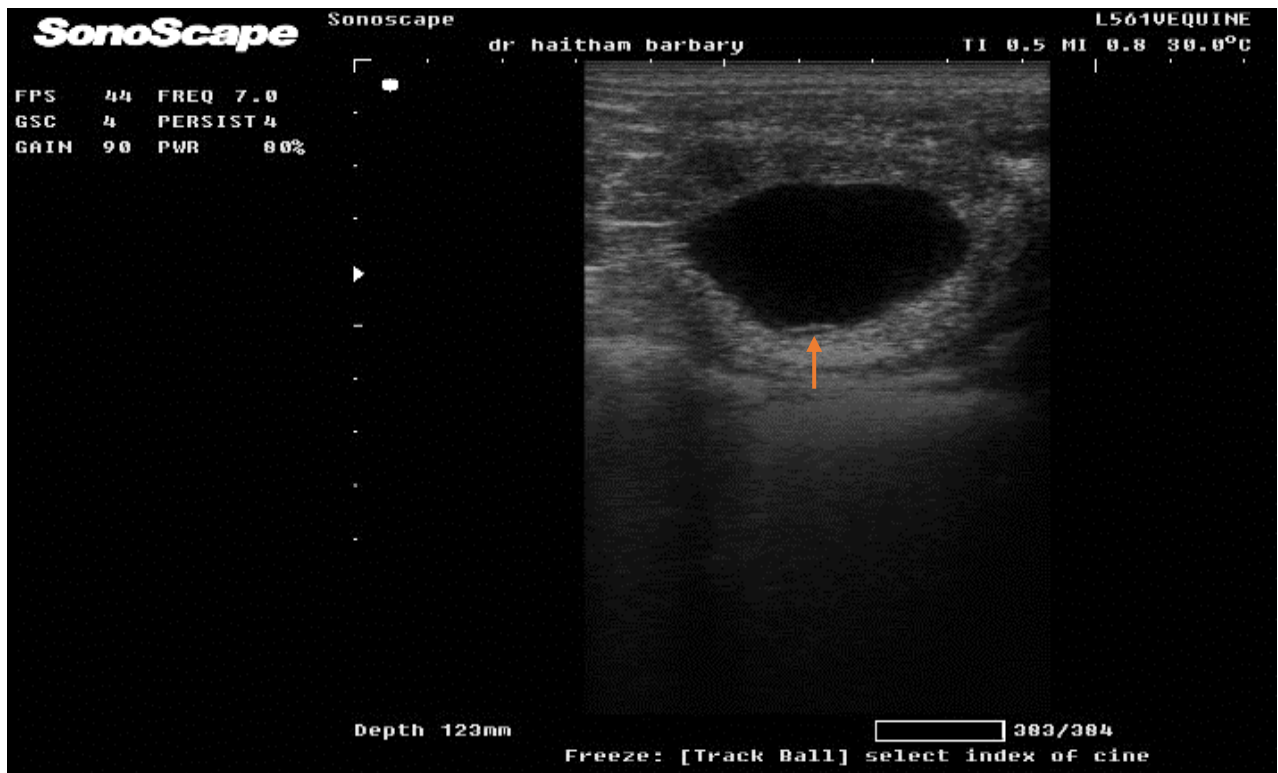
Ultrasonographic image of the embryonic sac on day 20 of pregnancy showed a hyperechoic embryonic mass at the bottom of the sac (arrow).
